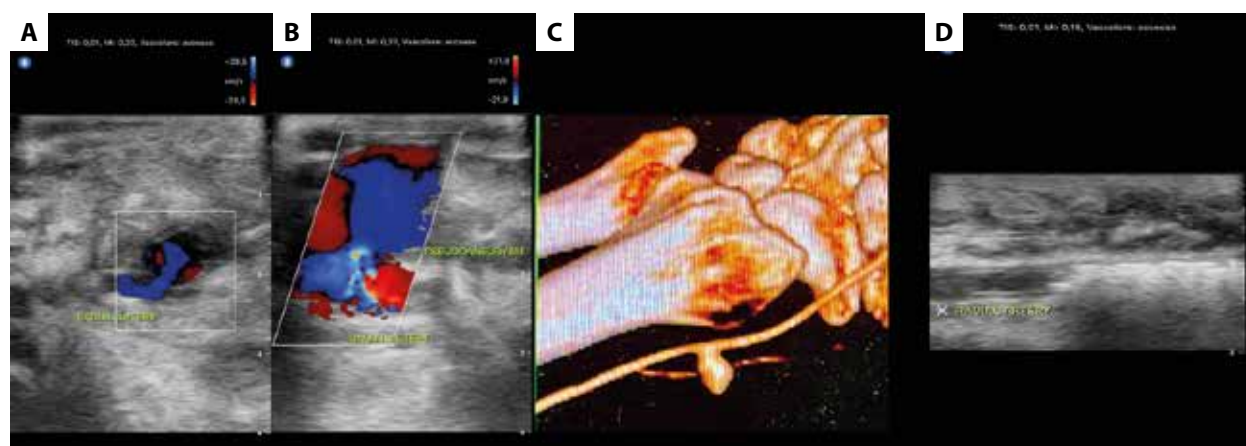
A. Pseudoaneurysm of the radial artery detected with a portable ultrasound device (Butterfly IQ+) upon admission to the medical ward. B. Increased size of pseudoaneurysm evaluated with a portable ultrasound device. C. Pseudoaneurysm evaluated by computed tomography. D. No blood flow after embolization evaluated with a portable ultrasound device
